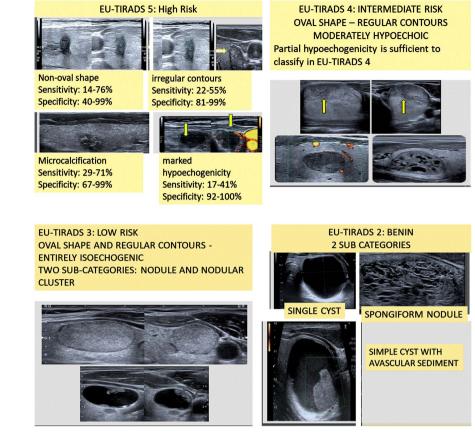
Ultrasound score, EU-TIRADS 2 to 5 nodule.
